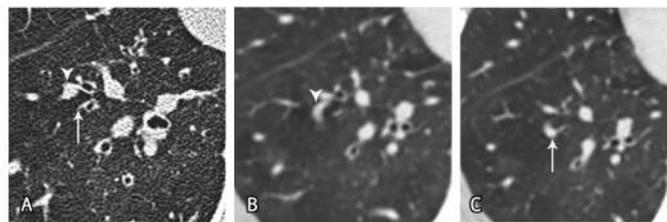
Pulmonary artery-to-pulmonary artery anastomosis in the anterior basal segment of the right lower lobe. An HRCT scan (A) showing that the thrombosed arteries (arrow) are almost absent next to the accompanying bronchi while the patent one is dilated (arrowhead). Two consecutive CT scans in the lung window (B, C) showing an anastomosis between the dilated patent artery (arrowhead) and the adjacent artery distal to the thrombosis (arrow)
